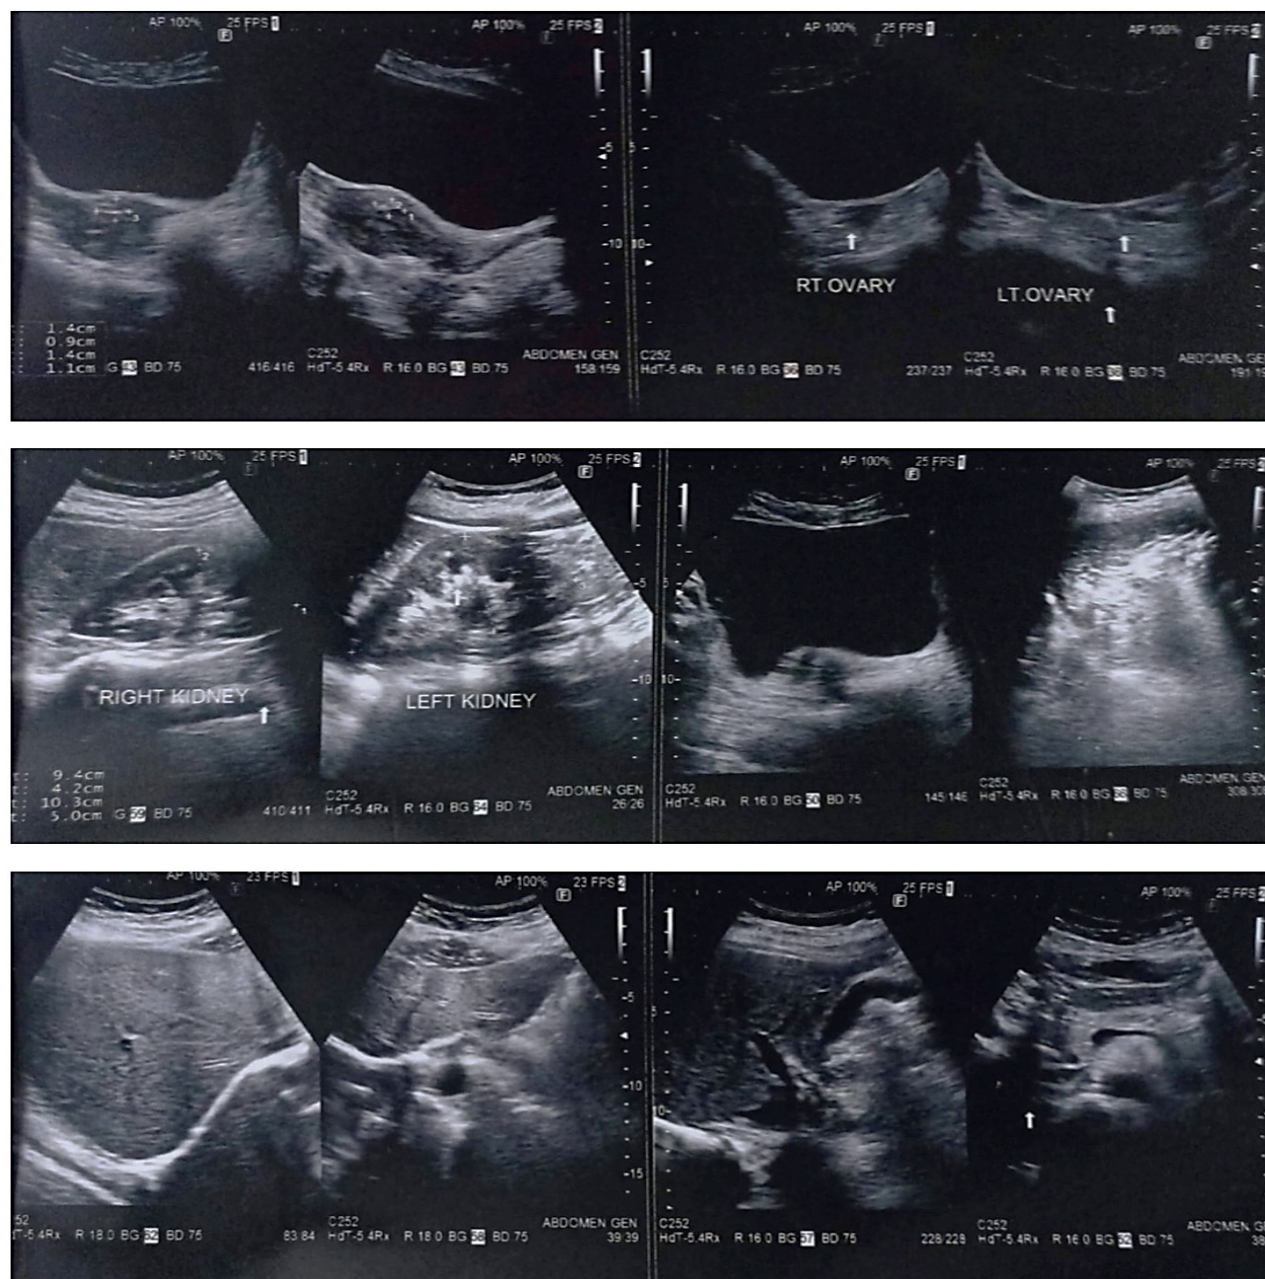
Real-time ultrasound sonography of abdomen and pelvis post treatment.
